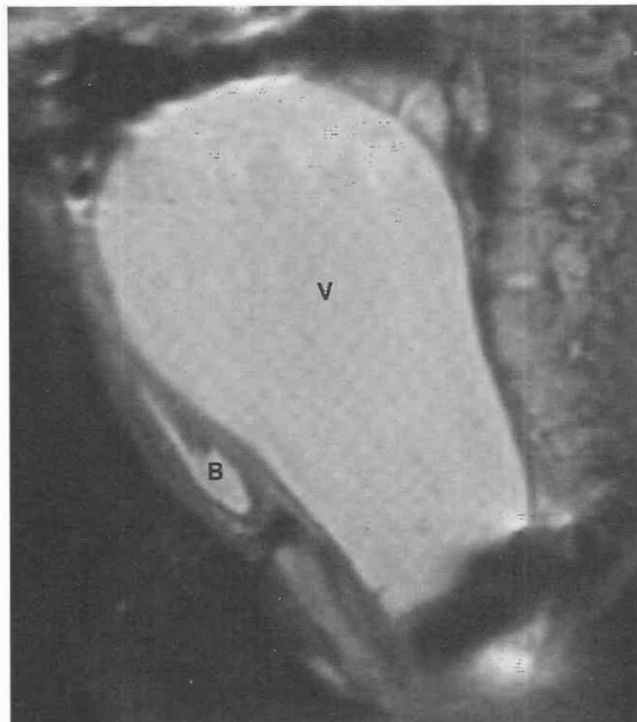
Hydrocolpos in a young girl with a large pelvic mass after resection of a sacrococcygeal teratoma. Sagittal T2-weighted fat-saturated (5000/120/180 degrees) image shows high-signal-intensity fluid in the dilated vaginal canal (V) posterior to the bladder (B). The hypointense band overlying the distal vagina represents a susceptibility artifact from a metallic clip.
